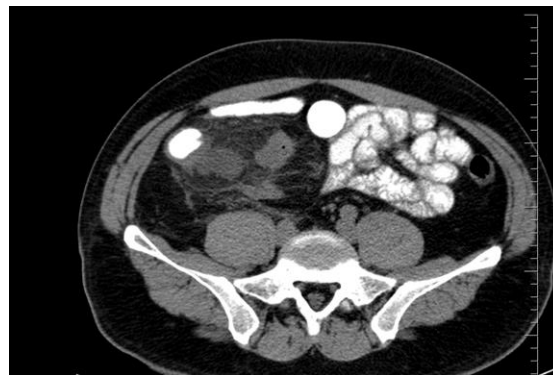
The arrow pointing to the lesion in cuadal CT scan section.
